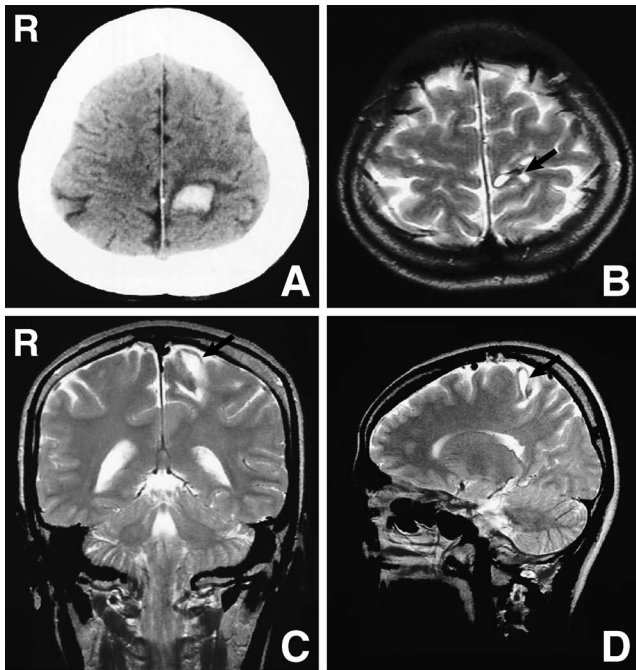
A: Computed tomography scan demonstrating an approximately 10-mm diameter subcortical hematoma in the left postcentral gyrus. B–D: T₂-weighted magnetic resonance images showing only a small hematoma (arrow).
